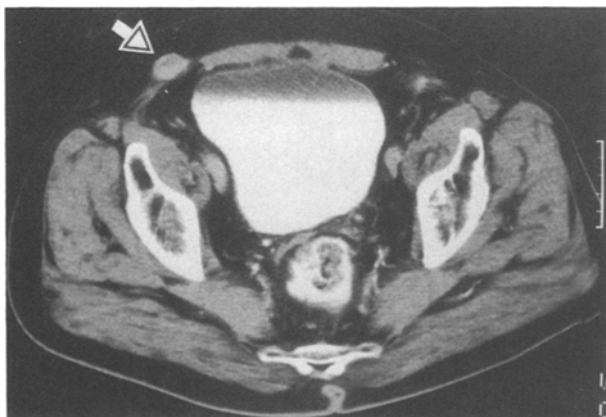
CT scan demonstrating abdominal wall mass (arrow).
